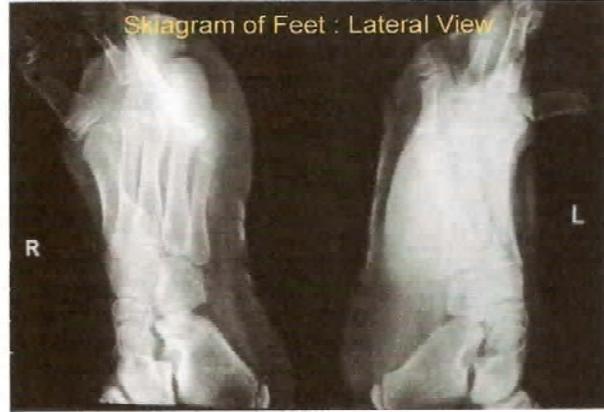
No. -2B Digital X-ray of feet - Lat. View
